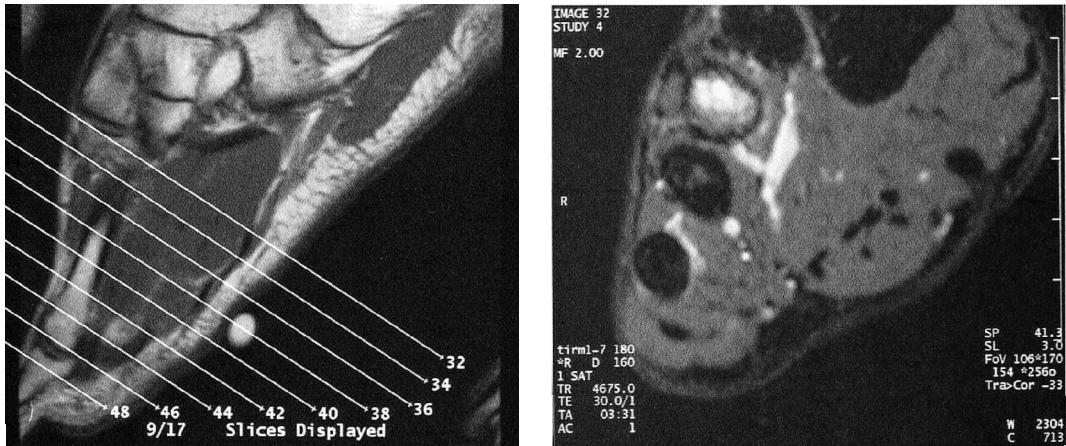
A 24-year-old male long distance runner who had persistent foot pain. MRI shows edema in the third metatarsal bone due to an overuse injury of bone without a fracture.
